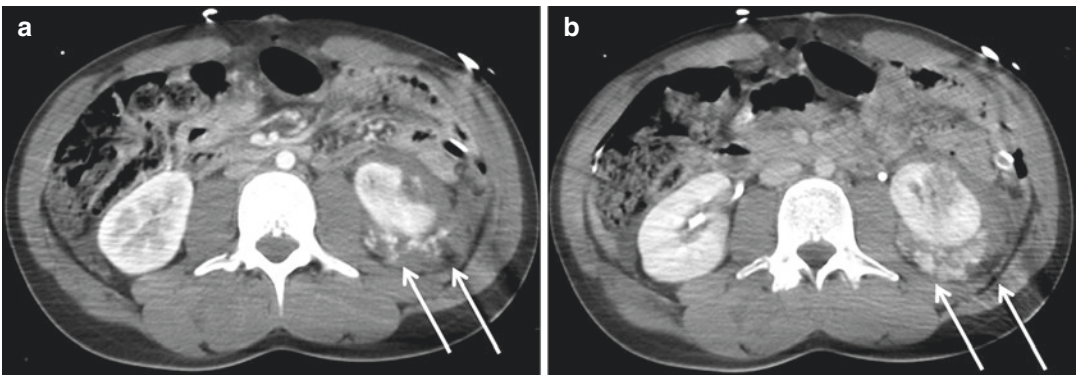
Contrast-enhanced CT scans in arterial phase (a) and venous phase (b) show the lower pole parenchymal injury, with perirenal hematoma; in both arterial and venous phases, active bleeding is evident (arrows)
